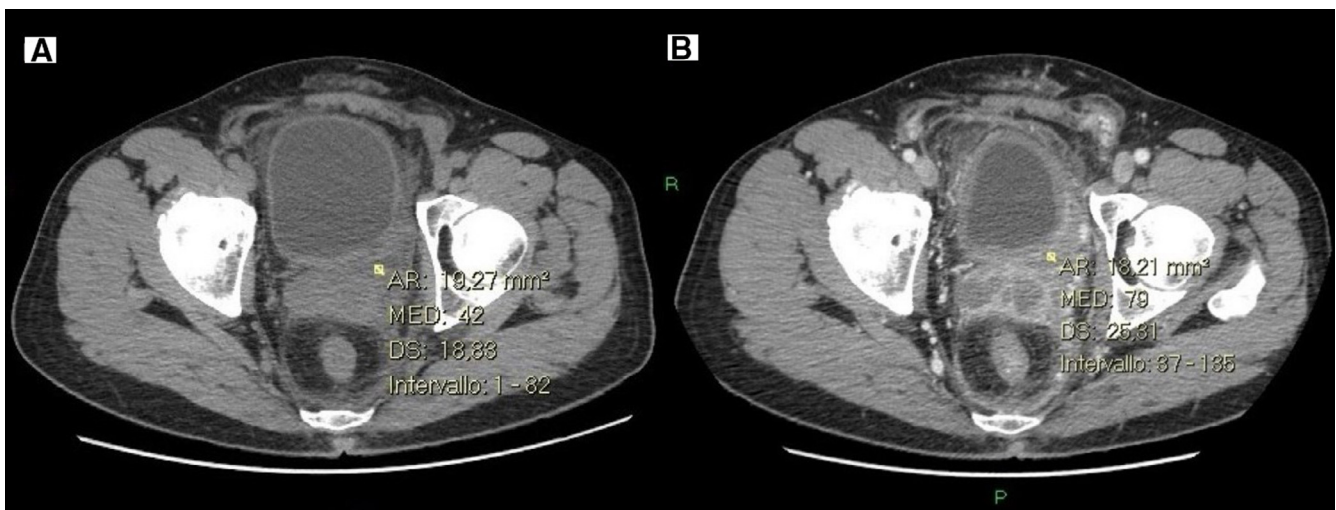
Abdominal CT in axial plane showing the presence of high density fluid collection with contrast enhancement.
